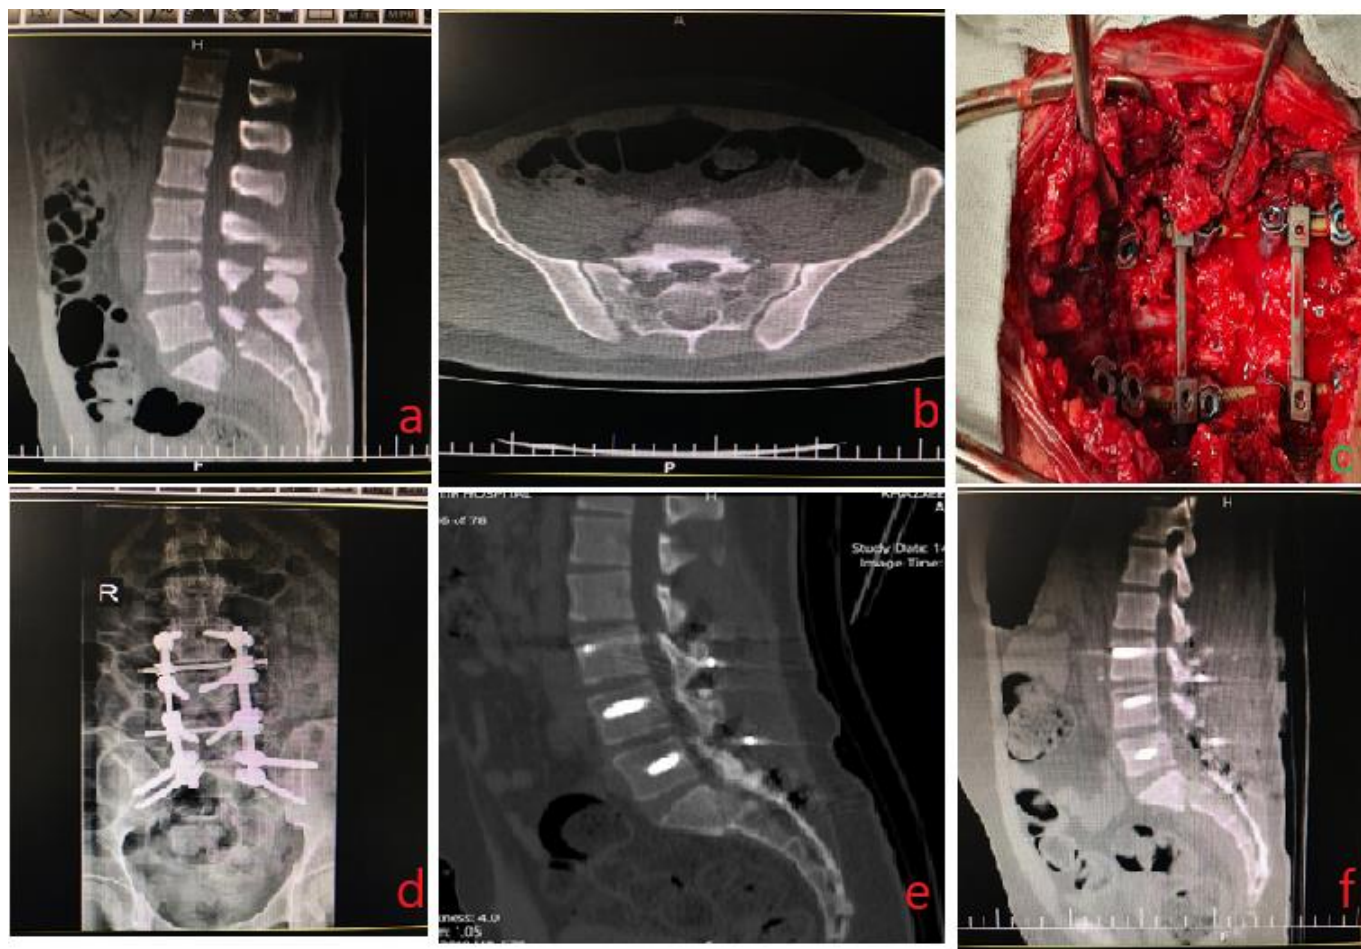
Preoperative CT scan in sagittal (a) and axial (b) views revealed S1-S2 spondyloptosis. We could see an intraoperative view after reduction (c). Just postoperative anteroposterior x-ray (d) and CT scan with sagittal reconstruction (e) revealed a promising reduction of deformity. After 2 years, the patient had no device failure and he had documented fusion in the interface of S1-S2 on sagittal CT scan (f).
